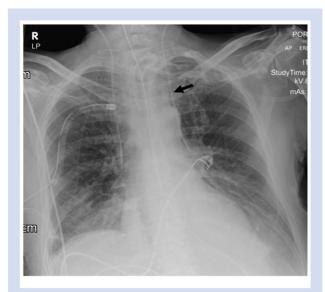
Chest radiograph showing the left internal jugular catheter projecting over the left mediastinum (arrow).
